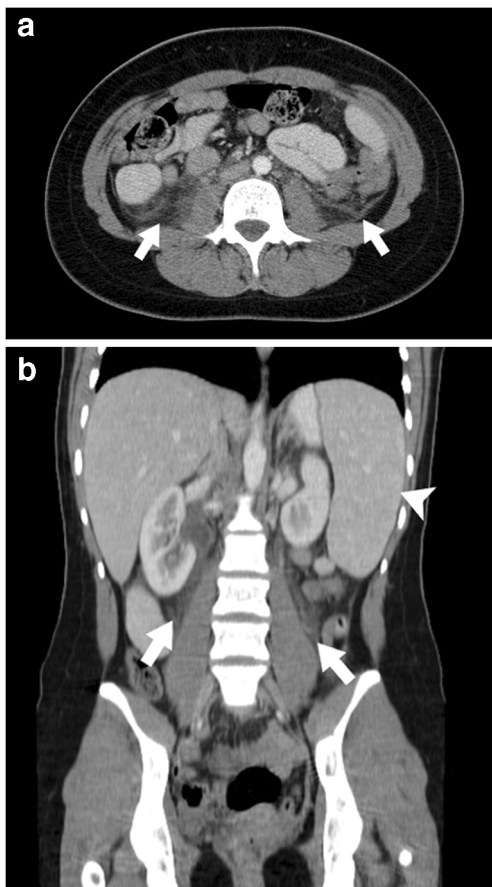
Familial Mediterranean fever in a 16-year-old girl with abdominal pain and vomiting. Axial (a) and coronal (b) contrast-enhanced CT images of the abdomen show a small amount of fluid and stranding of the fat in the retroperitoneum extending into the perinephric fat and into the paracolic gutters bilaterally in keeping with inflammatory changes in the retroperitoneum (arrows). Note also splenomegaly (arrowhead in b). Although rare in children, the differential diagnosis includes retroperitoneal fibrosis, which presents with fibrous tissue that envelops the great vessels and ureters with associated hydronephrosis, which can be idiopathic or secondary to prior surgery, malignancy, infection, autoimmune diseases (such as systemic lupus erythematosus or juvenile idiopathic arthritis) and drugs
